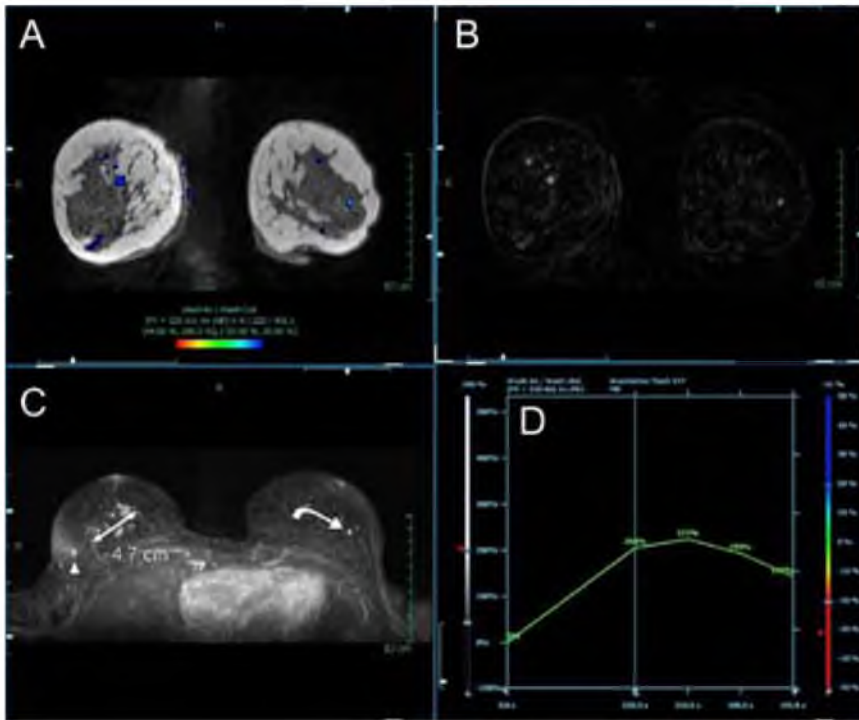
40 year old woman with strong family history for breast cancer, who presented with nipple discharge. The mammogram showed dense breast tissue with multiple benign calcifications and was thus negative (not shown). Microdochoectomy revealed LCIS. MRI was performed, showing a multifocal ILC over an area of 4.7 cm. Although most of the tumor showed continuous enhancement a small area was detected that showed early wash out of the contrast agent. (A: T1w FLASH 3D acquisition with color coded overlay of enhancement, the crosshair is placed at the machine detected spot with most suspicious enhancement curve, B: subtraction image of pre- and postcontrast MRI, C: maximum intensity projection, note the tumor area (double headed arrow), an ipsilateral intramammary lymph node (arrow head) and the biopsy proven fibroadenoma in the contralateral breast (curved arrow), D: machine detected most malignant enhancement curve (corresponding to the crosshair in A)).
